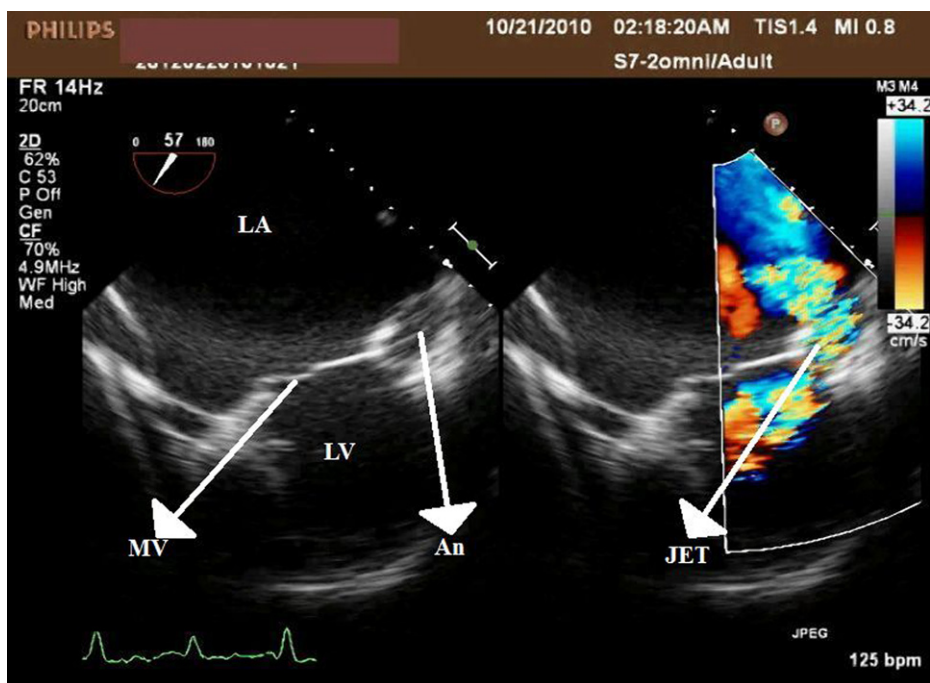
Transesophageal echocardiogram showing communication of pseudo-aneurysm with left atrium. LV = Left ventricle, LA = Left atrium, MV = Mitral valve, An = Aneurysm.
